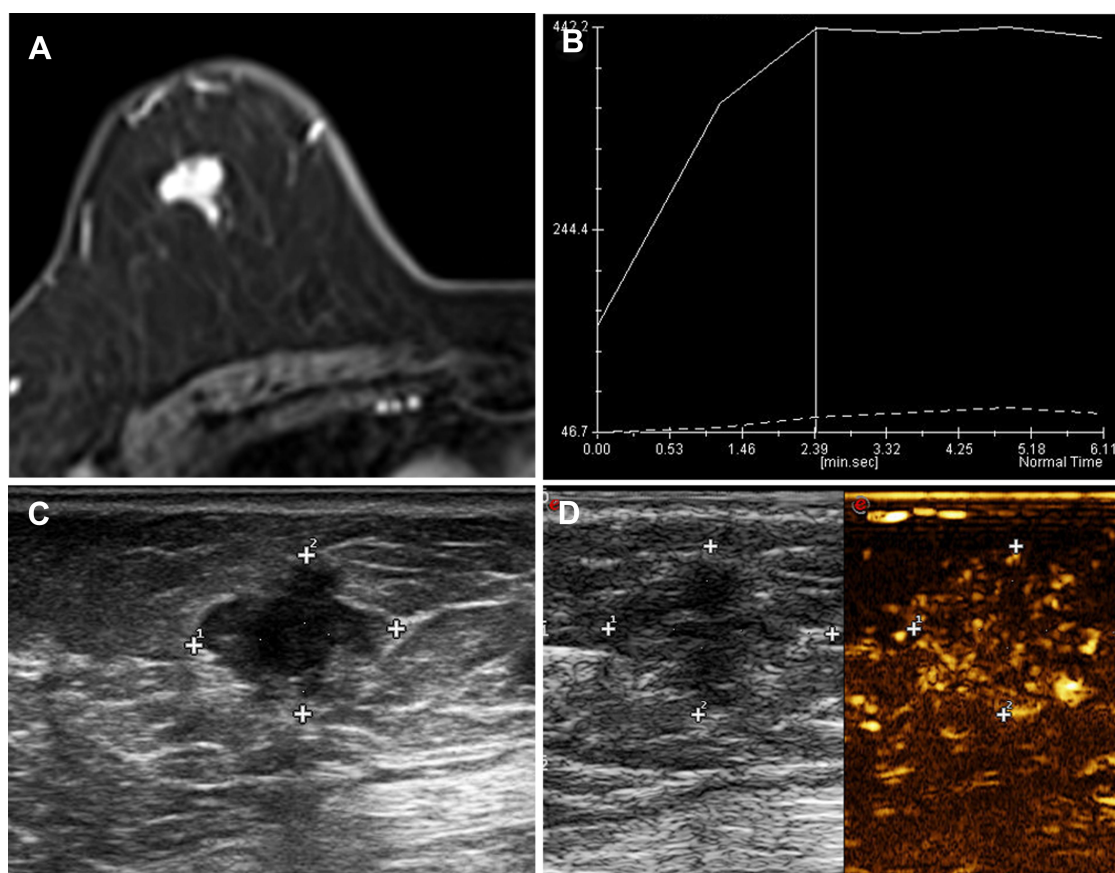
A 66-year-old female patient with a tough nodule in the right upper outer quadrant breast. (A) DCE-MRI showed an irregular mass with a size of about $16 \times 11 \times 11$ mm and an ADC value of about $0.84 \times 10^{-3} \text{ mm}^2/\text{s}$. (B) After enhancement, the TIC curve was plateau type and the edges were obviously not smooth. (C) The US presented an irregular hypoechoic lesion. (D) CEUS presented a heterogeneous enhancement and hyperenhancement enhancement; after enhancement, the range enlarged. The pathology result is invasive ductal carcinoma (IDC).
